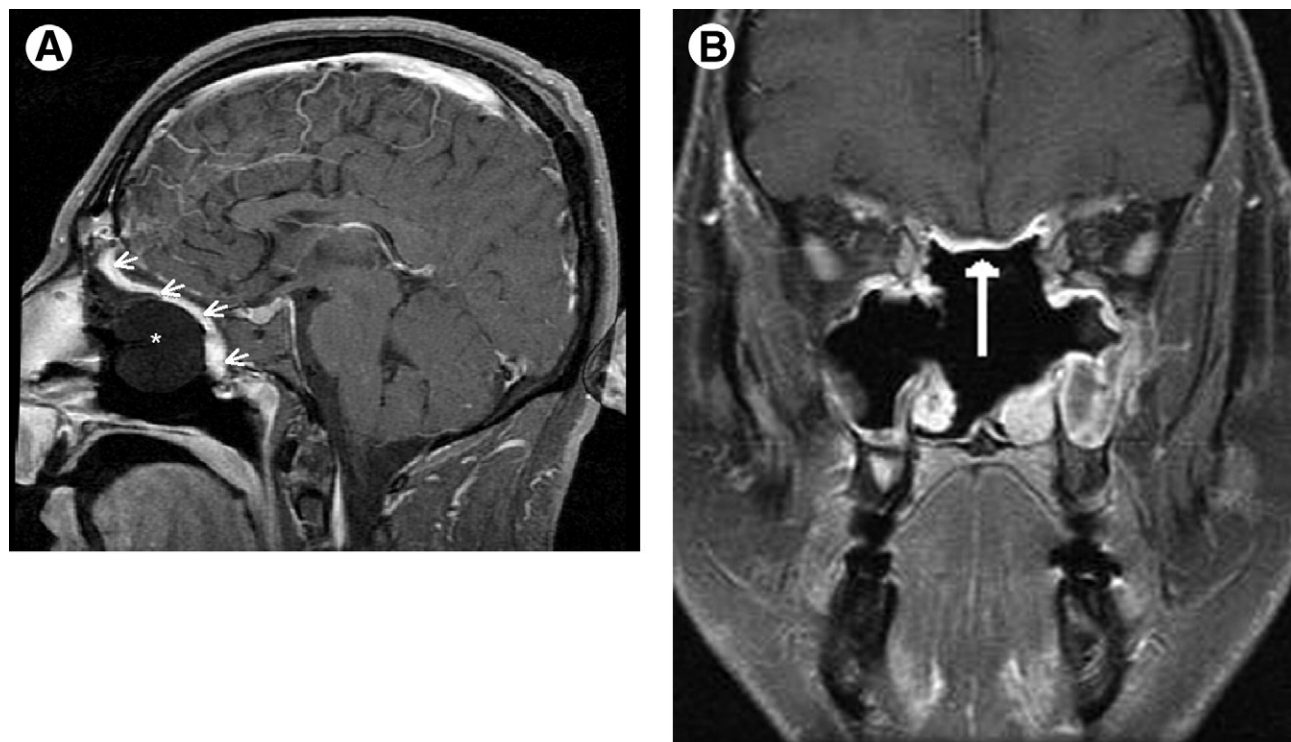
A postoperative computed tomography scan following an endonasal transcribriform approach showing the nasoseptal flap (arrows) in place. (A) The anterior-posterior extent of the nasoseptal flap is shown. The balloon catheter (*) is also seen in place. (B) The lateral extent of the flap is shown, spanning orbit to orbit.
